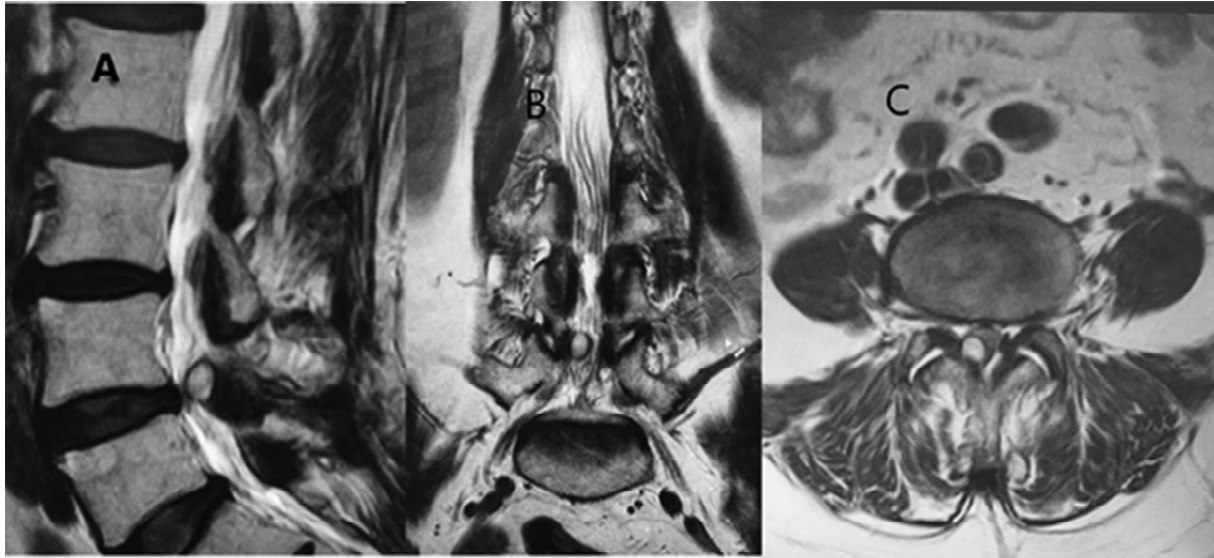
MRI of the lumbosacral spine T2 weighted images, A) Sagittal, B) Coronal and C) Axial views showing the characteristic cystic lesion (arrows) at L₄₋₅ disc level causing significant thecal sac compression.
